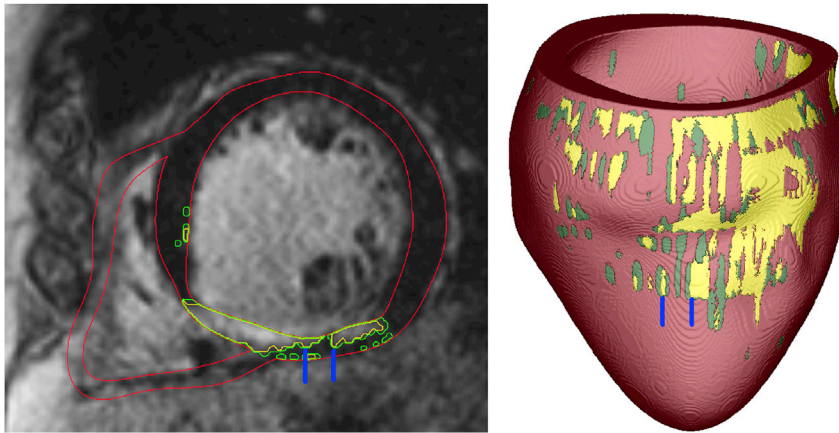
Left: a slice of an MRI image of one model. Red lines are the segmented ventricular boundaries, yellow lines are the segmented boundaries of core scar, and green lines are the segmented boundaries of the GZ. Right: the corresponding reconstructed model is shown. Blue lines demarcate the channel manifestation on the epicardial surface. To see this figure in color, go online.
